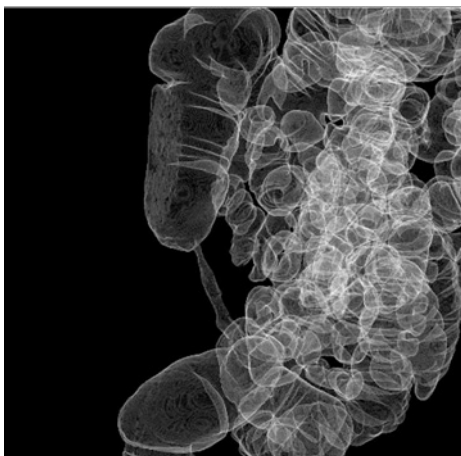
Stenotic lesion evaluated by 3D virtual multi-detector CT (MDCT) colonoscopy
